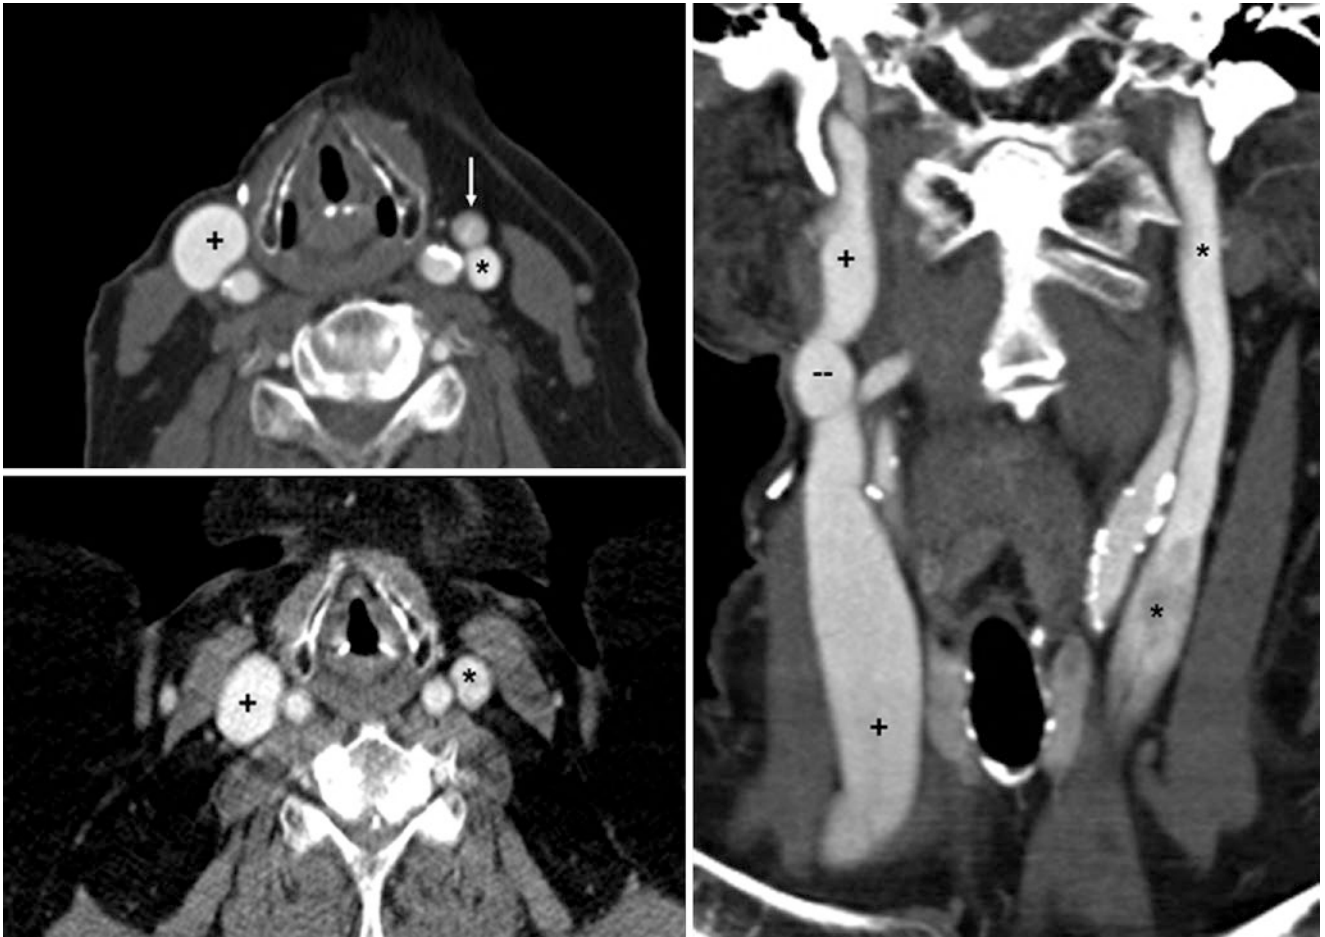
67-year-old with axial contrast-enhanced CT (CECT) to evaluate for metastatic nodes from tongue squamous cell carcinoma. An axial image (*top left*) shows that the right IJV (*plus sign*) is dominant (21 mm diameter), whereas the left IJV (*asterisk*) is borderline hypoplastic (8–10 mm diameter), an asymmetry also shown on coronal
